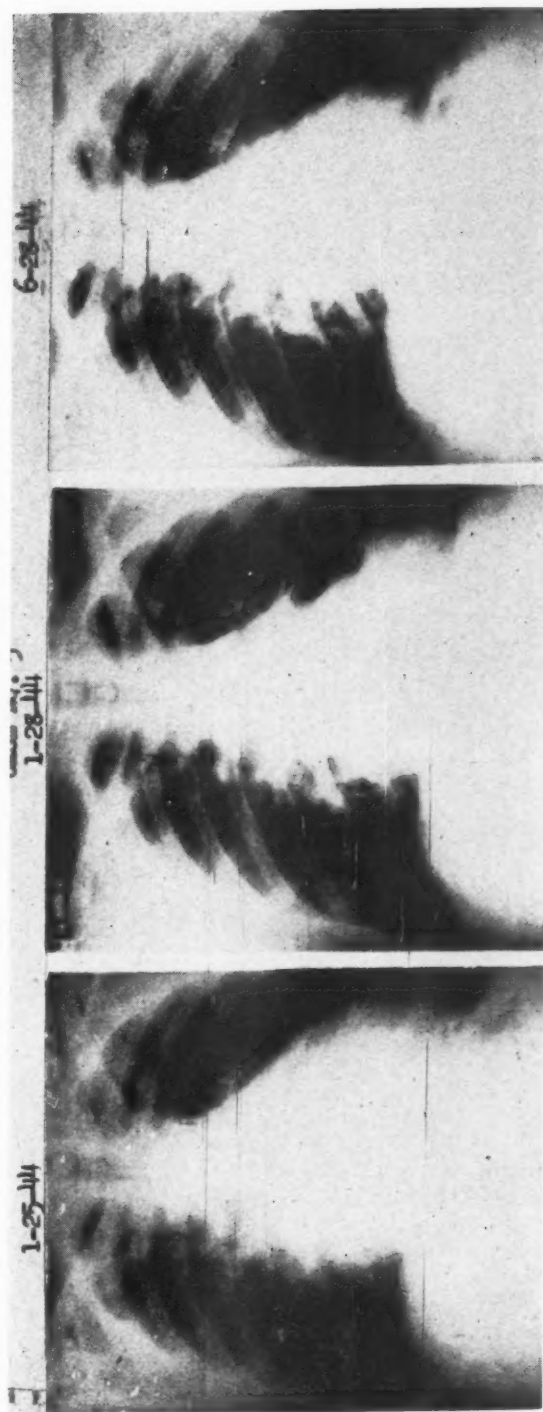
Case 5. The cardiophrenic angles remain acute although marked pericardial effusion is present. This x-ray was made on Jan. 28, 1944, after aspiration of 175 c.c. of hemorrhagic fluid and injection of 75 c.c. of air into the pericardial sac.
